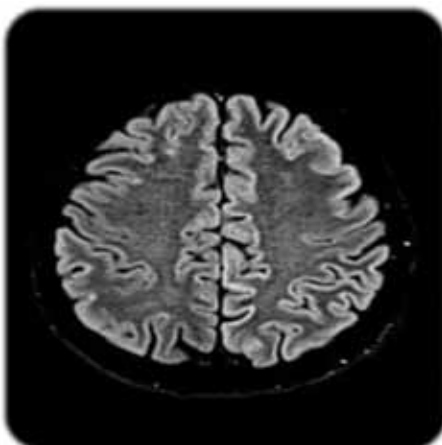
FLAIR sequence frontal and parietal cortex
